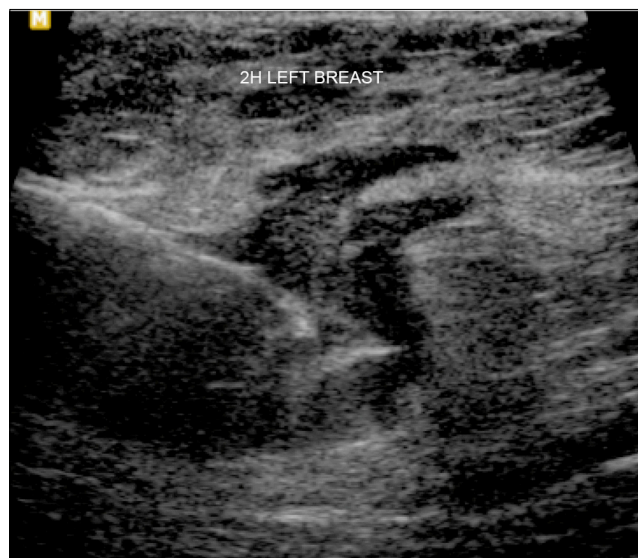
Ultrasound-guided core needle biopsy of the lesion.
